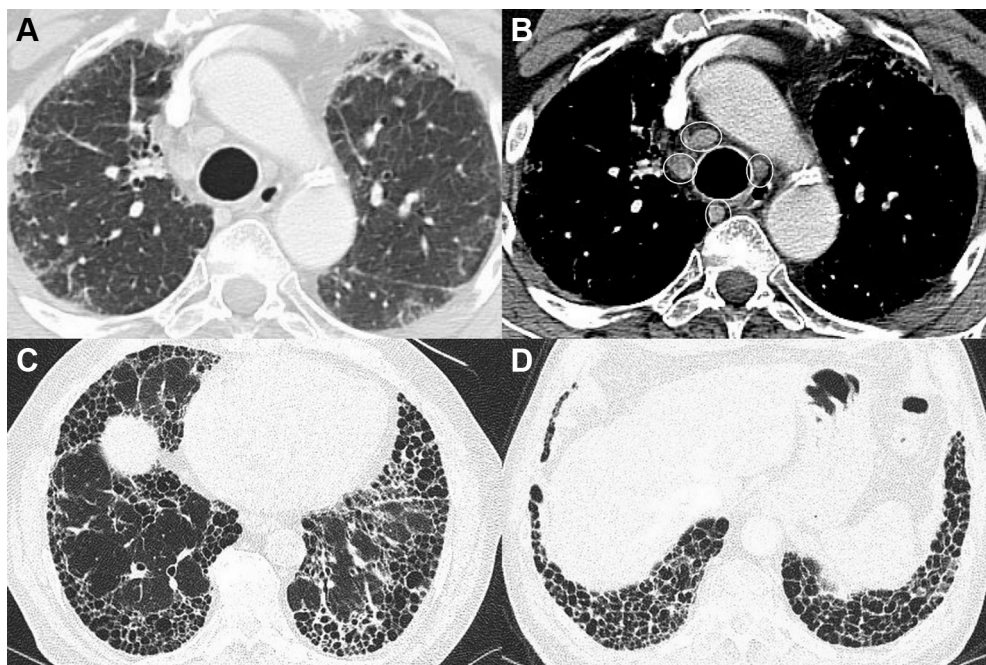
A-D, Axial high-resolution CT scans showing typical usual interstitial pneumonia with honeycombing or multilayered cysts with peripheral, subpleural, and basilar predominance (C, D) along with mediastinal lymphadenopathy (circled in B).
